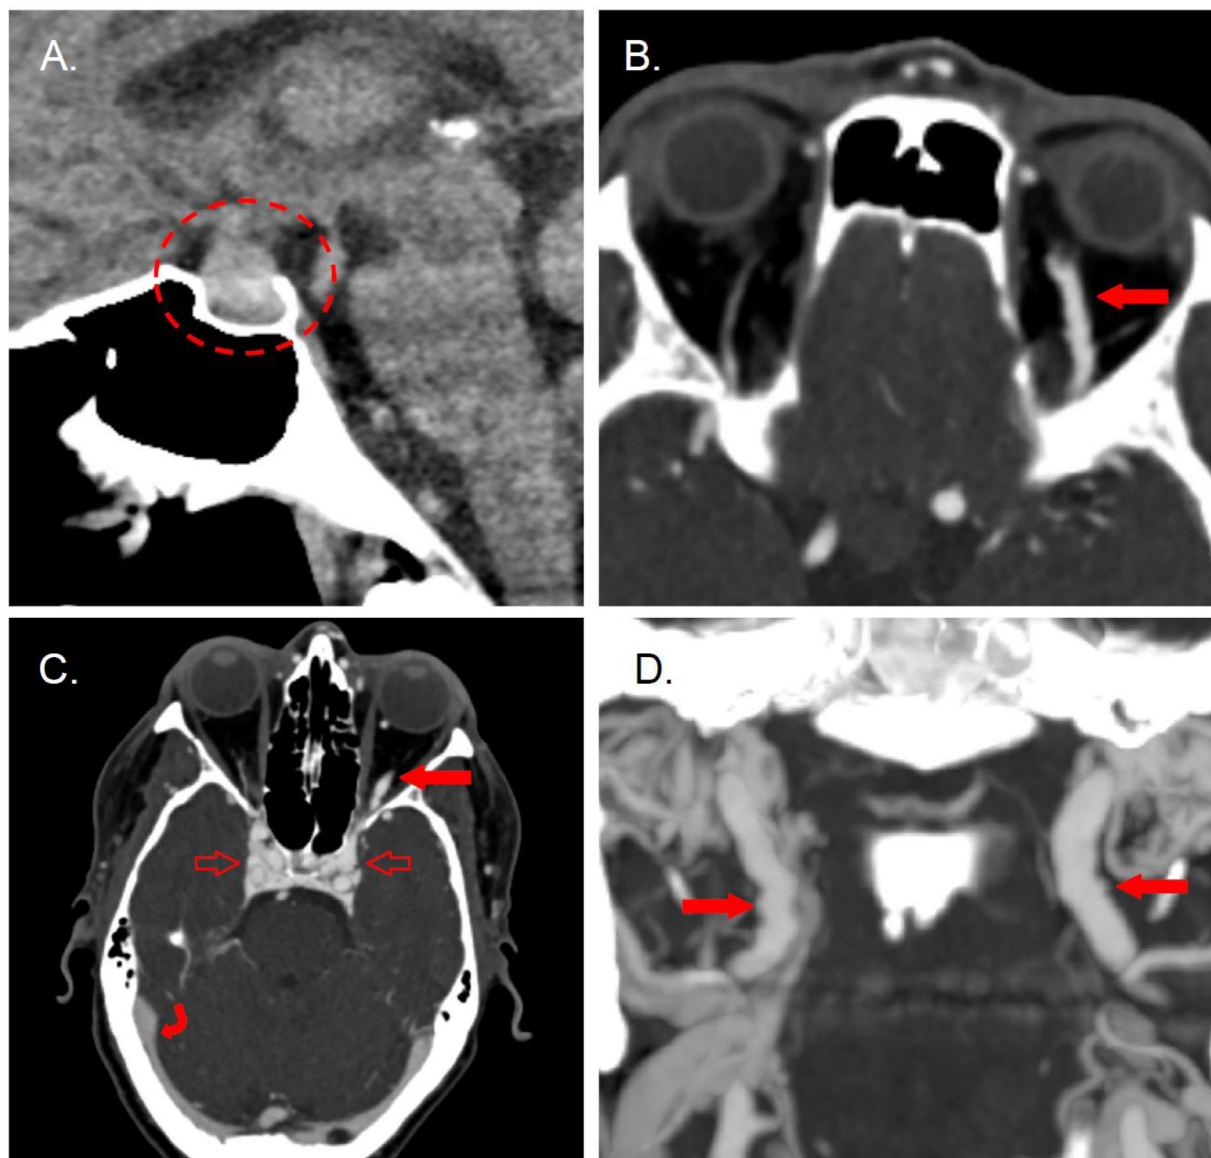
(A) Sagittal noncontrast CT of the head reveals further enlargement of the pituitary gland with cranial extension into the suprasellar cistern (dashed circle). (B) Axial CT angiogram of the head shows an enlarged left superior ophthalmic vein (solid arrow). (C) Axial CT angiogram of the head demonstrates enlargement of the left inferior ophthalmic vein (solid straight arrow), enlargement and early enhancement of the cavernous sinuses (open arrows). Expected venous enhancement is demonstrated in the dural venous sinuses (curved arrow). (D) Coronal maximum intensity projection (MIP) of the CT angiogram of the neck reveals a beaded appearance of both cervical internal carotid arteries (solid arrows).
